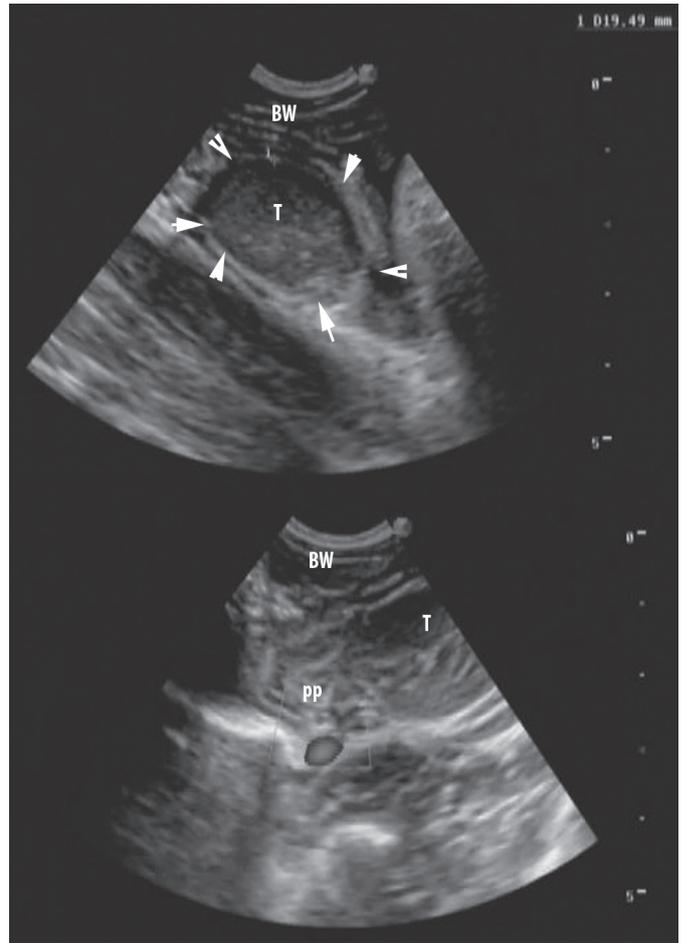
Ultrasonogram of intra-abdominal testis in a unilateral cryptorchid buck. BW= Body wall, T= testicle, pp=pampiniform plexus; abdominal testis is delineated by arrows
